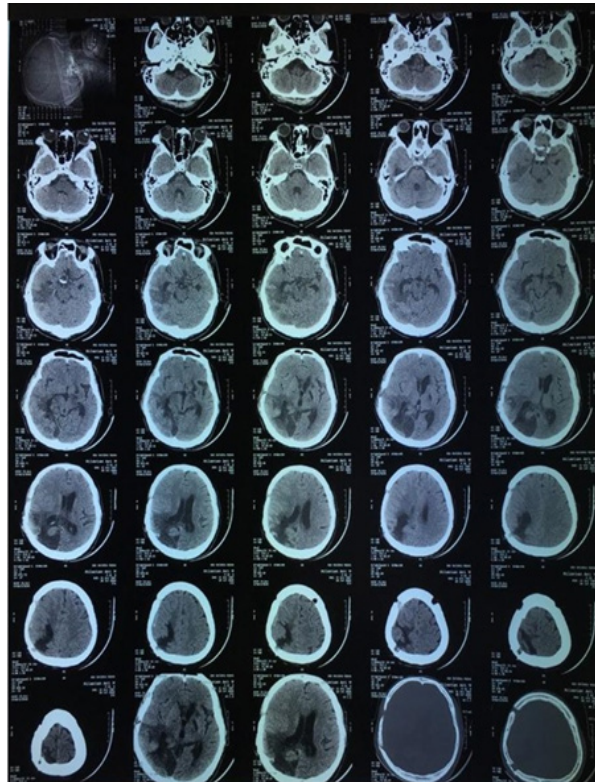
Follow up Head CT Scan Showed Post Right Parietal Decompressive Craniotomy with Normal Brain Imaging Finding
